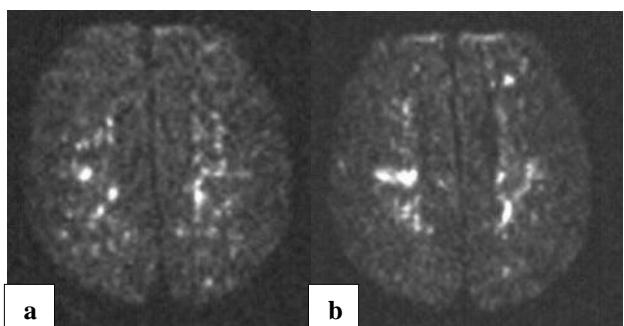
MRI of brain: showing foci of ischemia (a) post-op day 2 showing multiple hypertension areas consistent with multiple emboli, and (b) post-op day 14 shows evolving cortical infarctions.³
